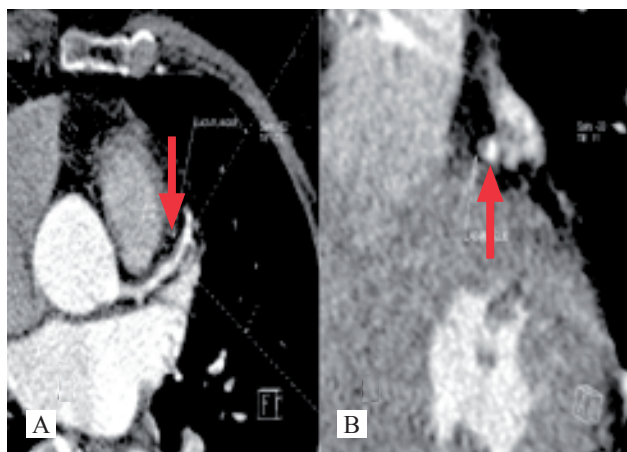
Images from a 68 years old woman with unstable angina, hypertension and hyperlipidemia. Tangential reconstruction image (A) showed $<50\%$ DS in the LAD (arrow) with an irregular-surface plaque (15mm in length and 2.2mm in thickness) and a cross-sectional image of the dash line (B) showed mild stenosis with a low-density plaque (83 HU, arrow). Coronary angiography showed no stenosis while intravascular ultrasound showed endothelium dissection of LAD, and a stent was implanted.
